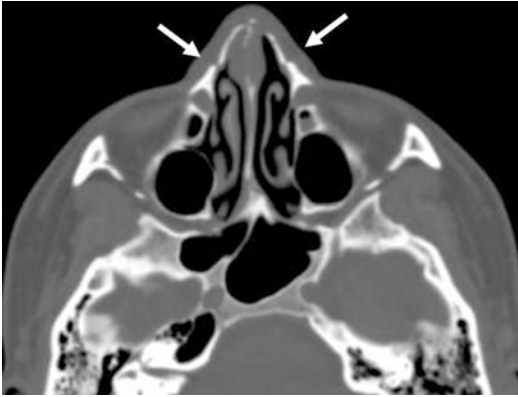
Axial CT scan: nasal bones fracture in women (white arrows)
